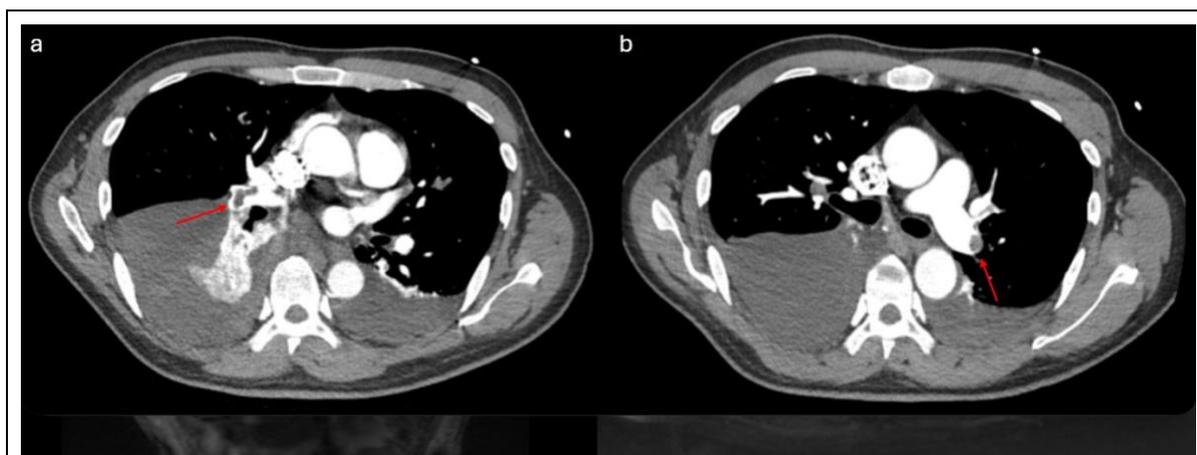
CT angiography demonstrating bilateral pulmonary embolism involving distal right (a) and distal left (b) pulmonary arteries.
